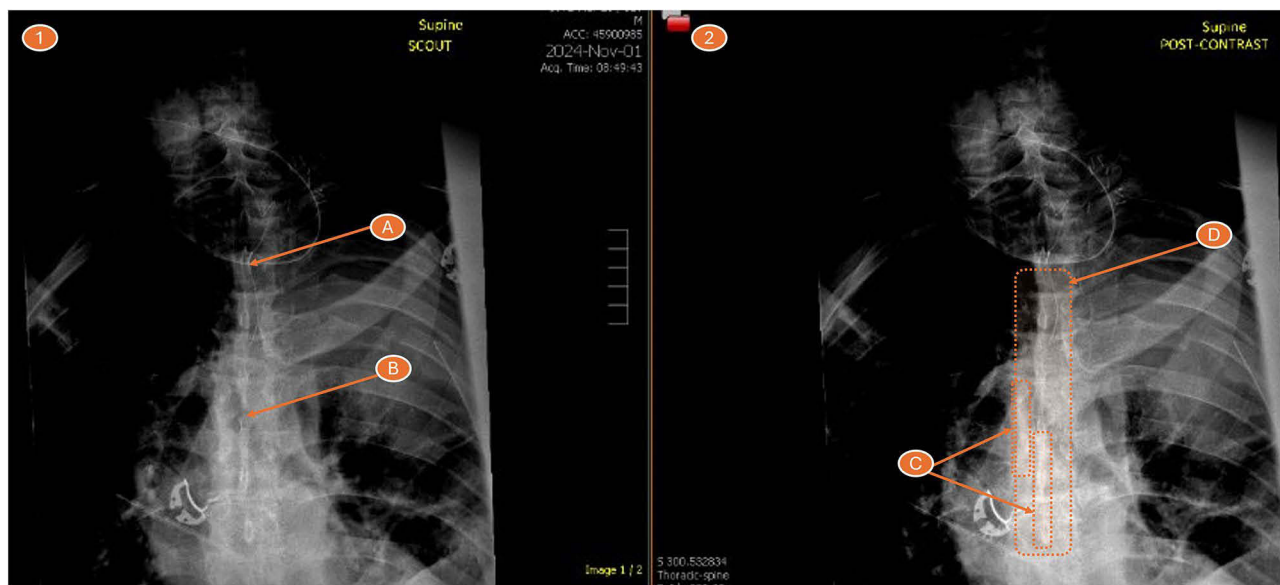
The postoperative epidurogram demonstrating pre- (1) and post- (2) contrast T-spine X-ray. (A) Epidural catheter insertion site (T1-T2). (B) Epidural catheter end site (T6-T7). (C) Concentrated areas of contrast. (D) Contour of contrast spread within spinal canal between T3-T9.
